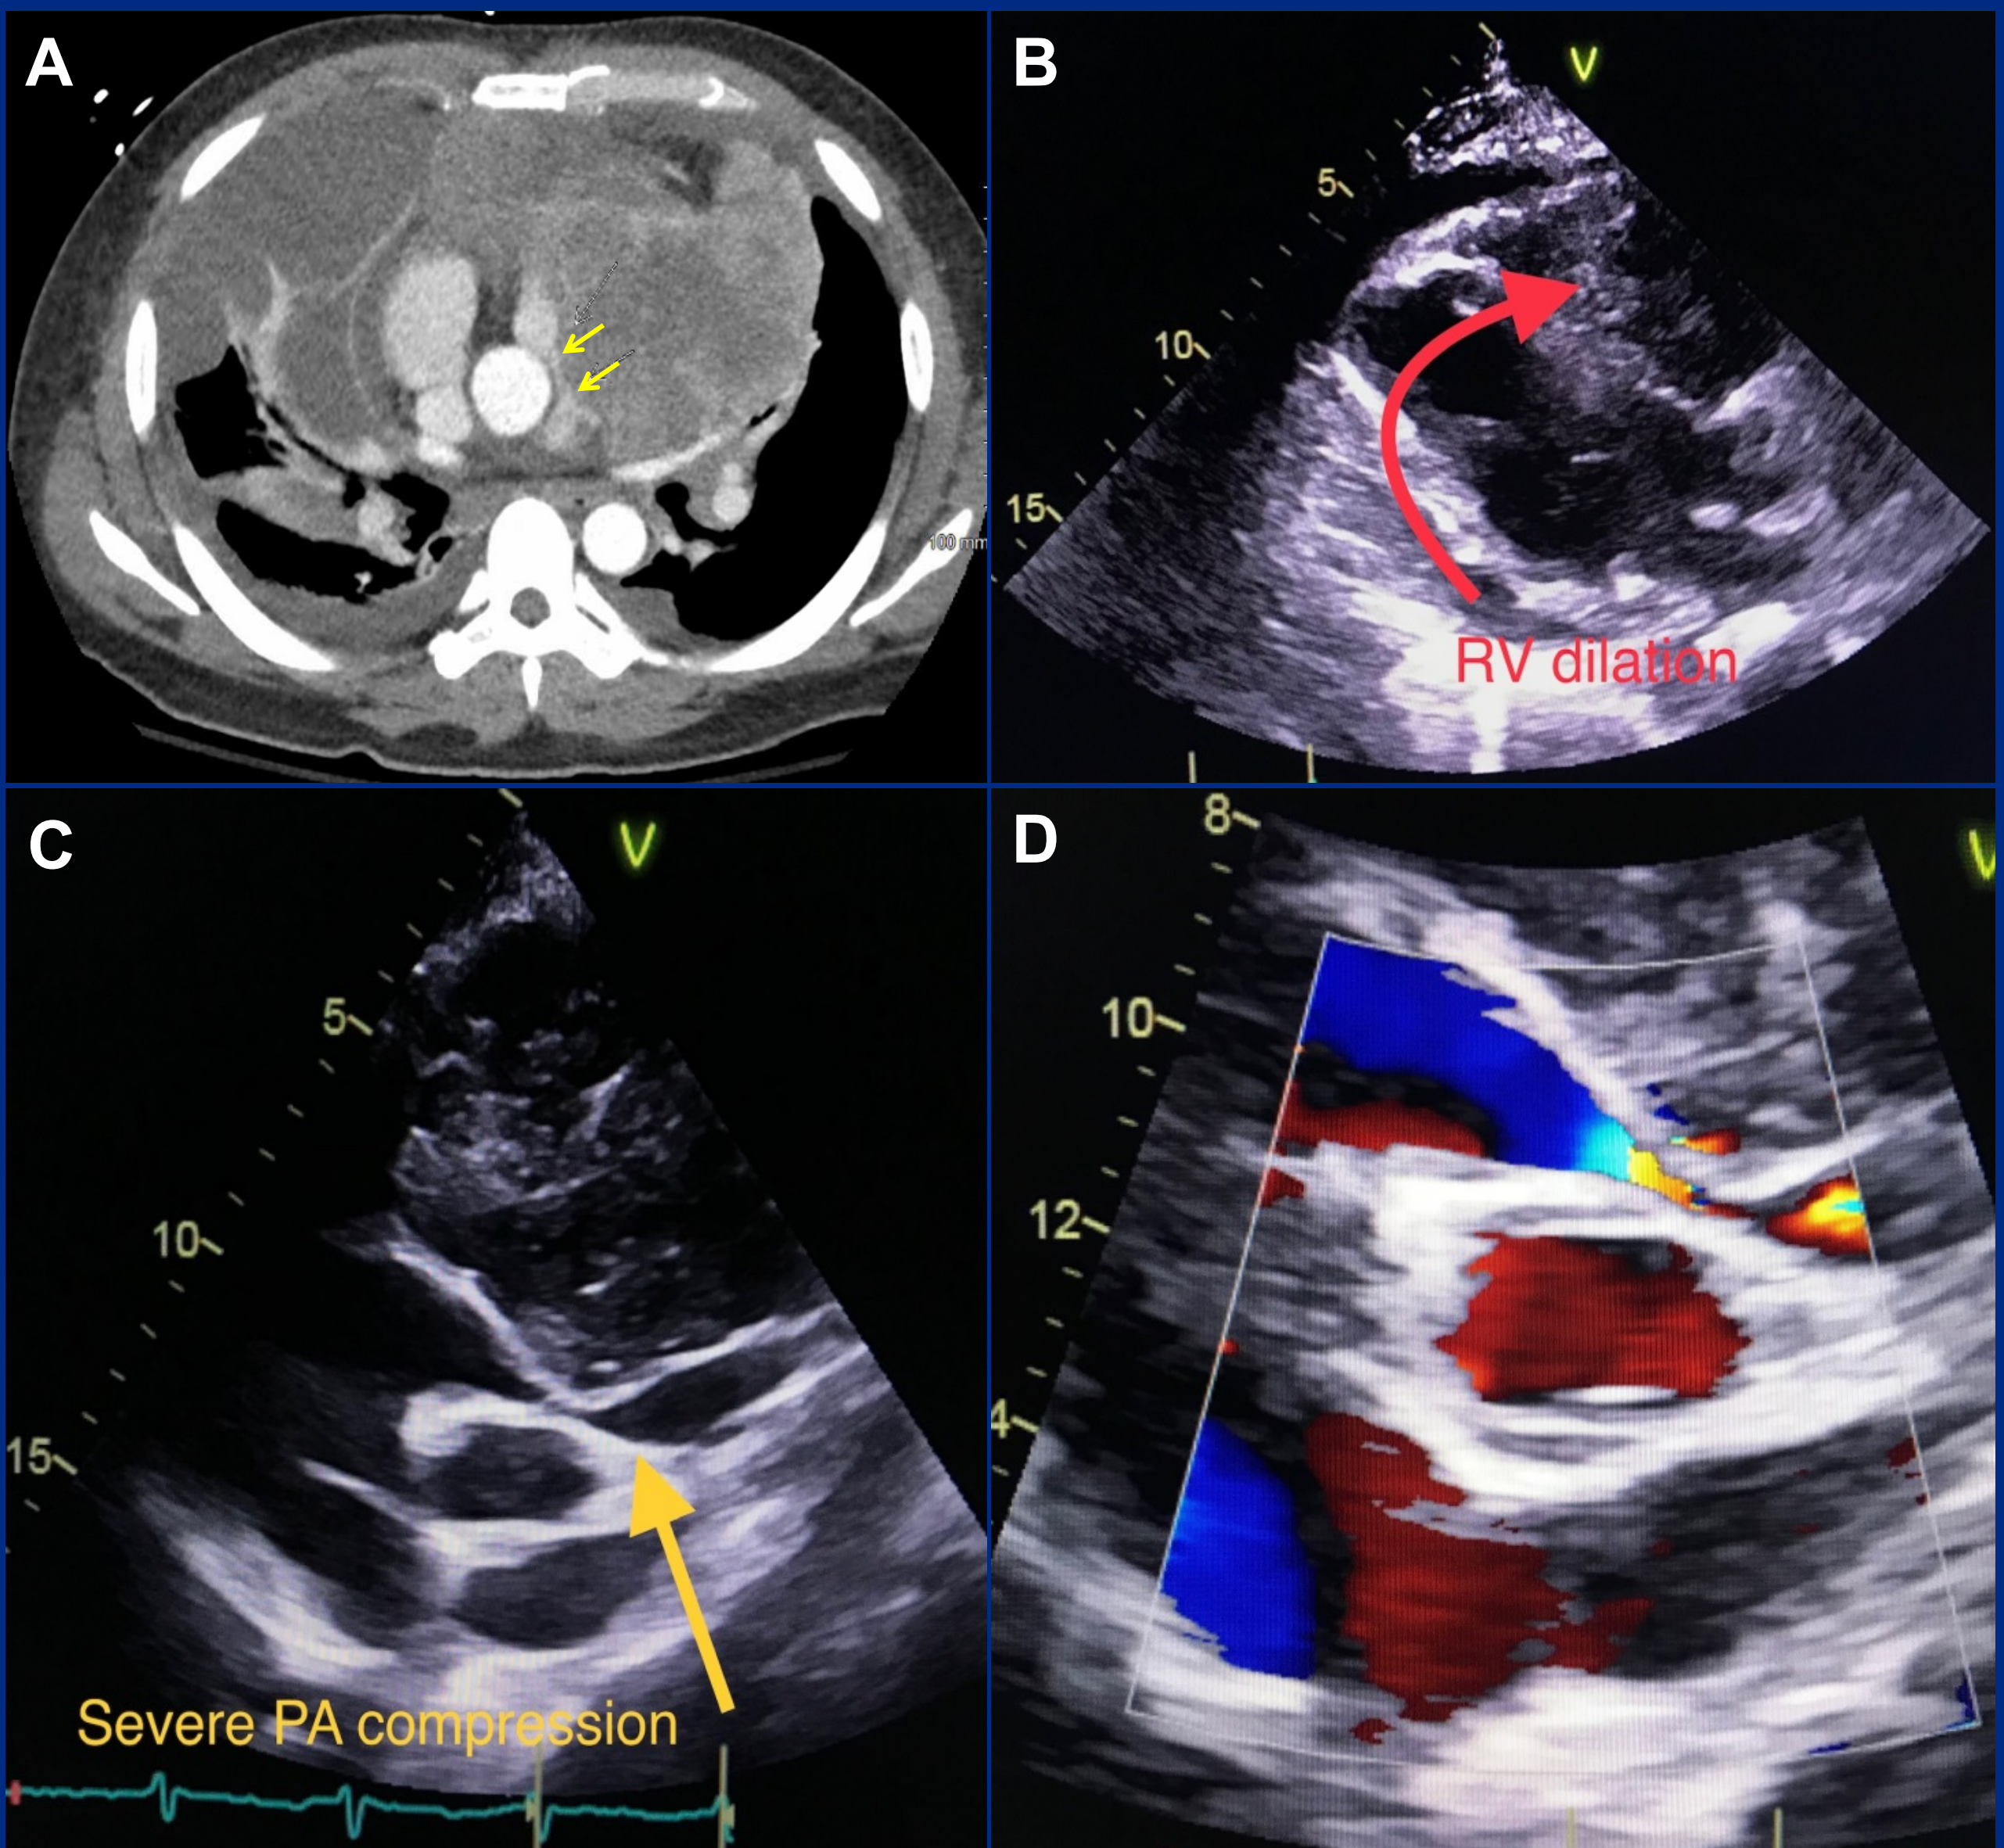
A. CT angiography demonstrated a large, heterogeneous anterior mediastinal mass compressing the main pulmonary artery (yellow arrow). B. Two-dimensional (2-D) transthoracic echocardiogram (TTE) showed dilatation of the right ventricle and plethoric IVC. C. Severe PA compression by mass. D. Doppler flow with elevated velocities at the area of stenosis.
